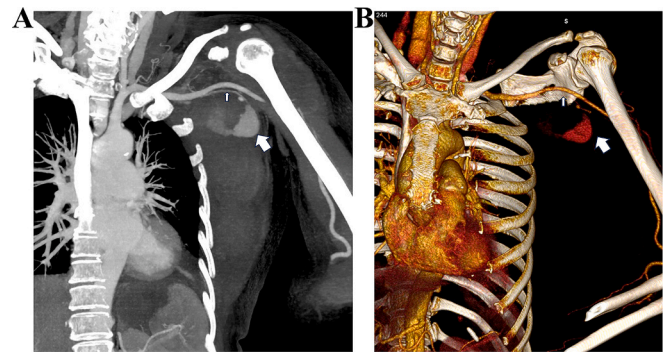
CT angiography. (A) The pseudoaneurysm in the left axilla ruptured to form a hematoma (The thin white arrow points to the lateral thoracic artery, and the thick white arrow points to the ruptured pseudoaneurysm). (B) 3D reconstruction of blood vessels suggests lateral thoracic artery rupture and pseudoaneurysm formation (The thin white arrow points to the lateral thoracic artery, and the thick white arrow points to the ruptured pseudoaneurysm).
